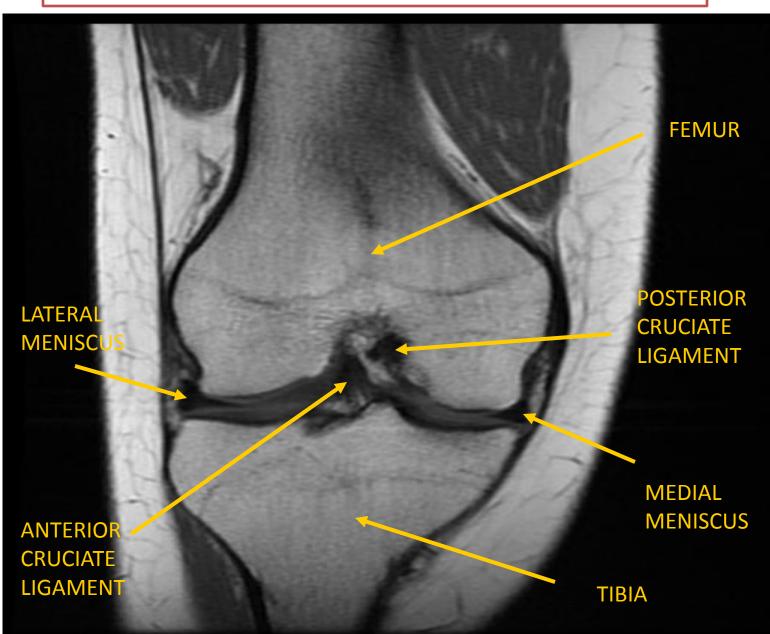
Coronal T1-weighted magnetic resonance image (MRI) of the knee in an adult male. (By courtesy of Dr Justin Lee, Chelsea and Westminster Hospital, London.)
